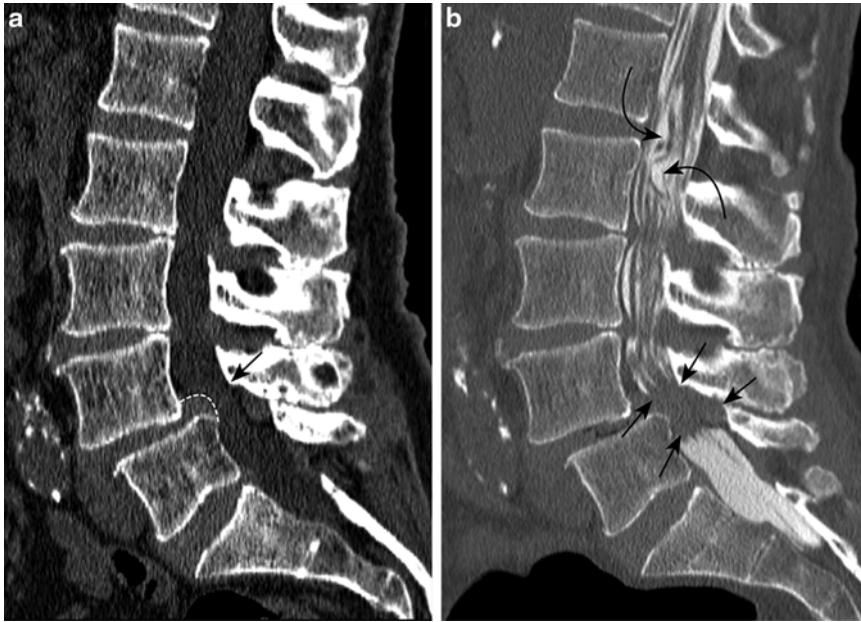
Myelography in spondylolisthesis. (a) Reformatted sagittal CT image demonstrates anterolisthesis at L4–5. The L4–5 intervertebral disc is uncovered as it remains aligned with L5 (*dotted line*). Central spinal canal stenosis is evident (*arrow*). (b) Image from a CT myelogram demonstrates a
